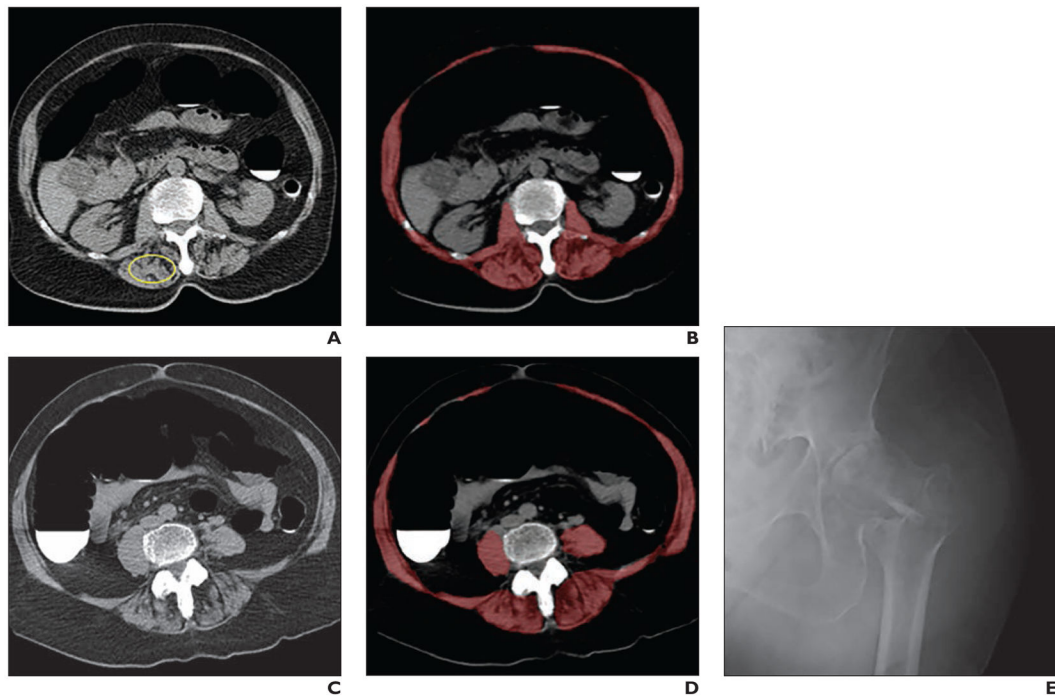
Sarcopenia (myosteatosis) at screening CT colonoscopy in 79-year-old woman with subsequent hip fracture.
